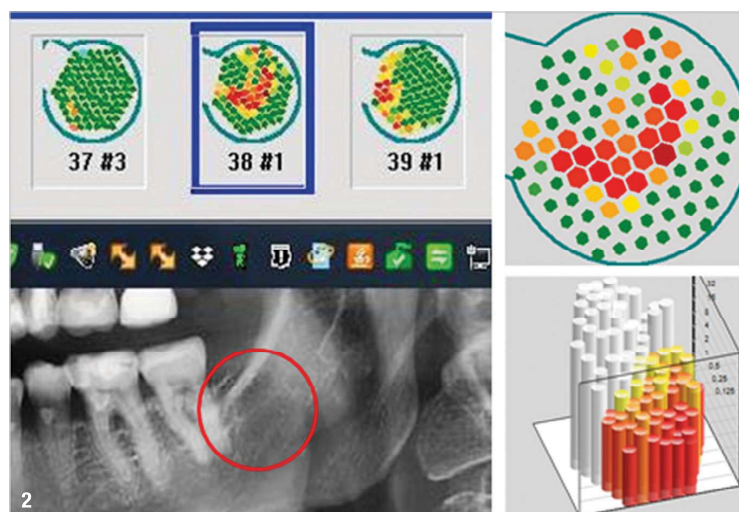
Example of an inconspicuous radiographic image in area #38 (red circle). In contrast, measurement of bone density in area #38 compared with healthy tooth #37 (top left) with ultrasound shows conspicuous red areas in 2D and 3D representation (right).
